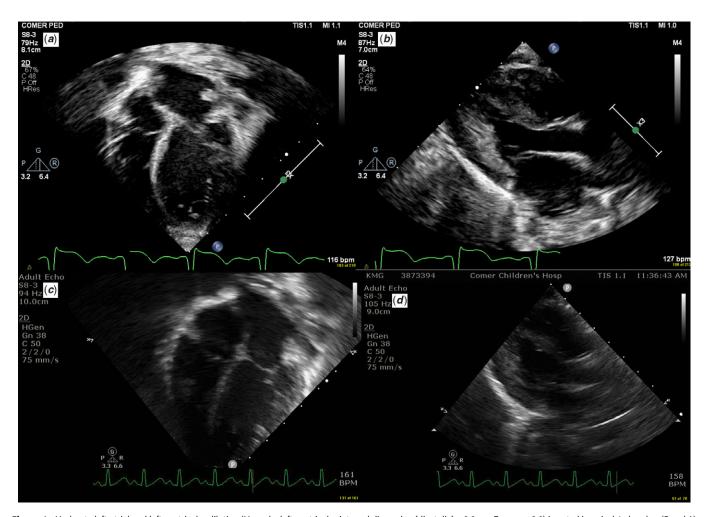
Moderate left atrial and left ventricular dilation (M-mode: left ventricular internal dimension [diastolic] = 2.8 cm, Z score = 3.8) is noted in apical 4-chamber (Panel A) and parasternal long-axis (Panel B) views at 2 months of age. The same views show complete regression of left atrial and left ventricular (M-mode: left ventricular internal dimension [diastolic] = 2.9 cm, Z score = 2.0) enlargement at 7 months of age (Panels C and D).
